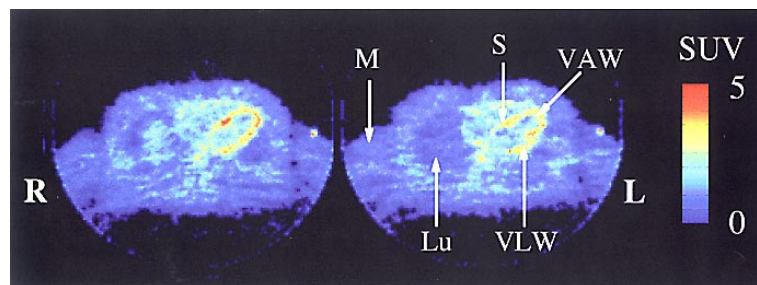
PET images of radioactivity in the chest region of a human after intravenous injection of [^{11}C]TMSX. The [^{11}C]TMSX PET images were acquired for 25 min starting at 10 min after injection. The radioactivity level was expressed as the standardized uptake value (SUV, g body weight \times Bq/ml tissue/total injected dose). L, left side; R, right side; VLW, left ventricular lateral wall; VAW, left ventricular anterior wall; S, interventricular septum; Lu, lung; and M, brachialis muscle.
